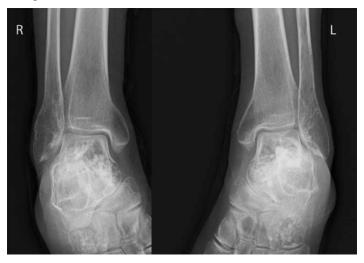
Radiographic image of the bilateral ankles at the time of the initial visit. Multiple bone cysts are observed in both the ankles showing characteristics of NHD.
